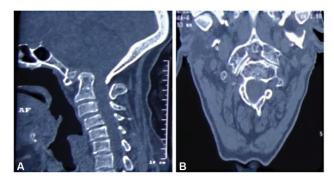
Noncontrast computed tomography (CT) craniovertebral junction (CVJ). (A) sagittal view and (B) axial view, showing atlantoaxial dislocation (AAD) with basilar invagination (BI).
